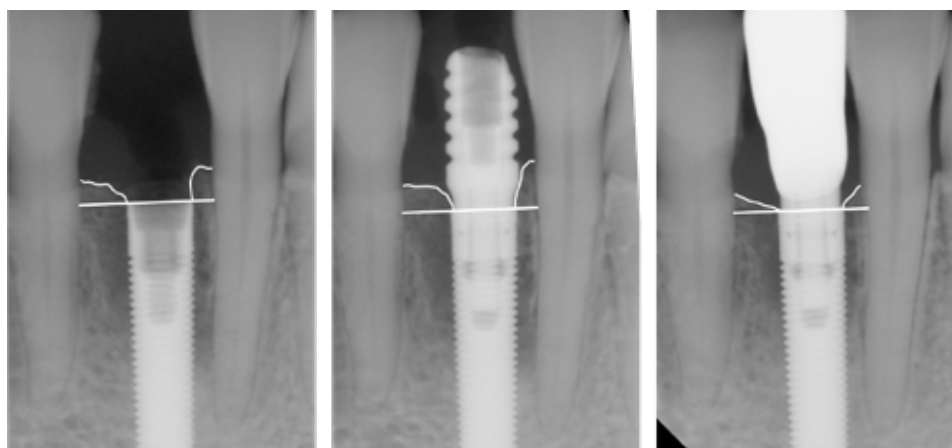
Standardized periapical radiographs performed at t0 (implant placement), t1 (4-month healing with screw-retained provisional) and t2 (1-year load with final restoration); Reference points for the linear measurements were the most coronal margin of the implant collar and the most coronal point of bone-to-implant contact. Bone loss changes were obtained subtracting the bone level at t0 from the bone level at t1 and t2.
